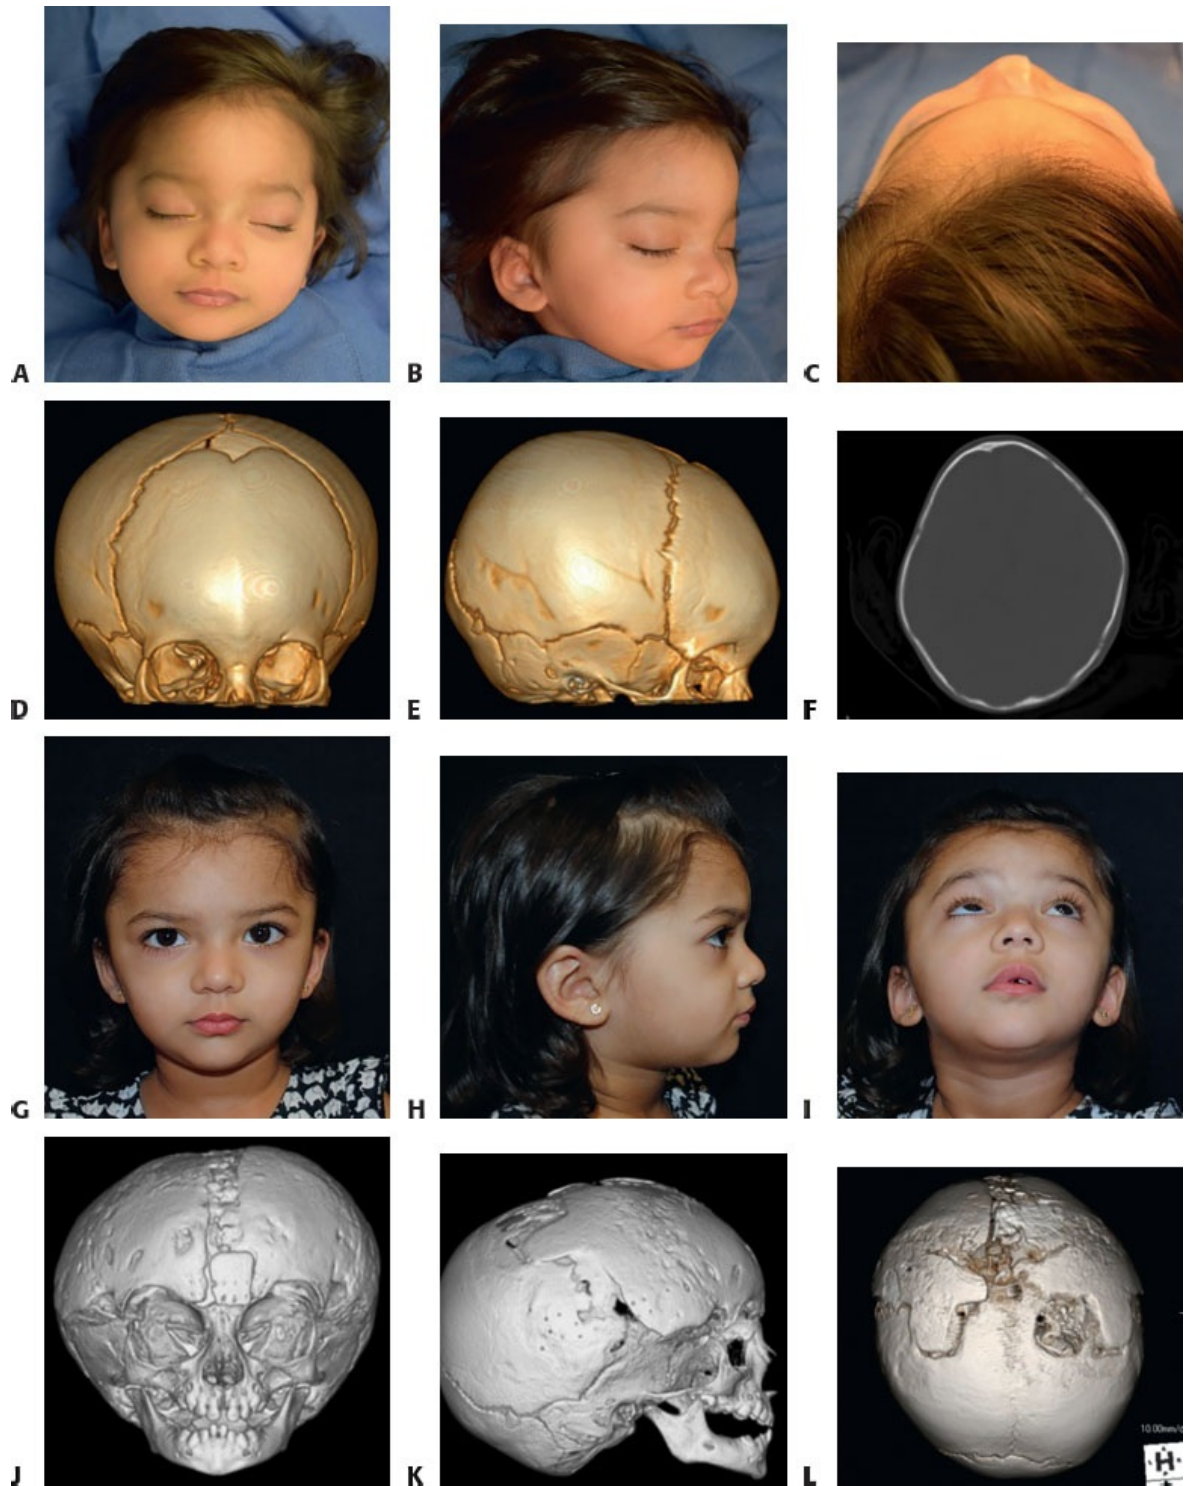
• Girl with metopic synostosis. Preoperative photographs (A–C) and CT scans (D–F) at 8 months of age. Postoperative photographs (G–I) and 3D CT scans (J–L) at 25 months of age (17 months postoperatively).
